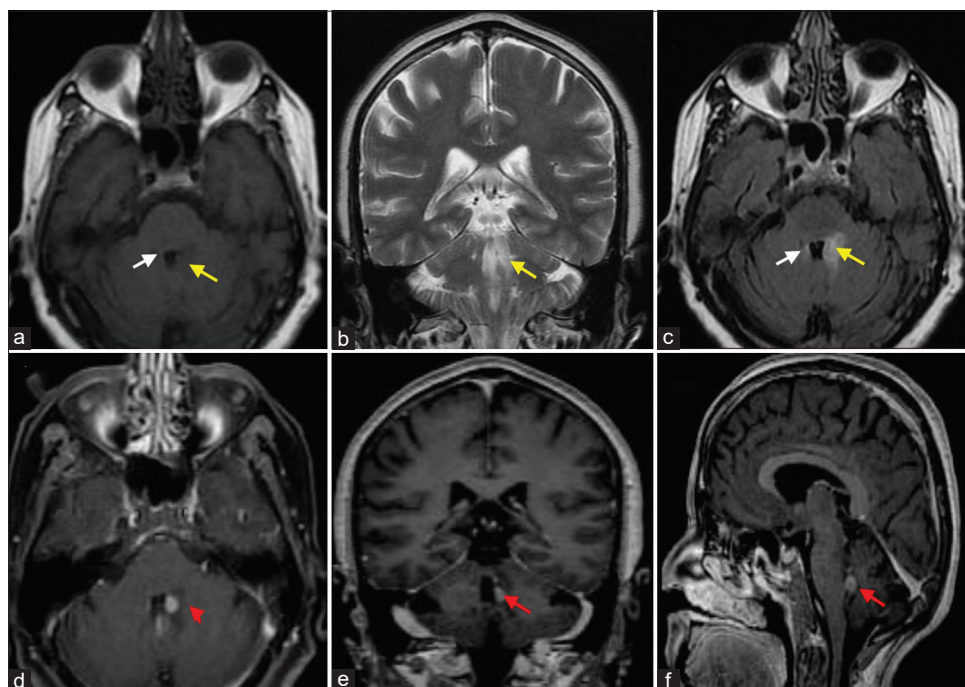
(a) Axial T1W shows a hypointense mass lesion in the left lateral wall of the fourth ventricle (yellow arrow) and it appears isointense on T2W sequence (b; yellow arrow) and hyperintense on FLAIR sequence (c; yellow arrow) adjacent to fourth ventricle (white arrow). T1W postcontrast (d; axial, e; coronal, f; sagittal) shows nodular enhancement of the lesion (red arrow)
